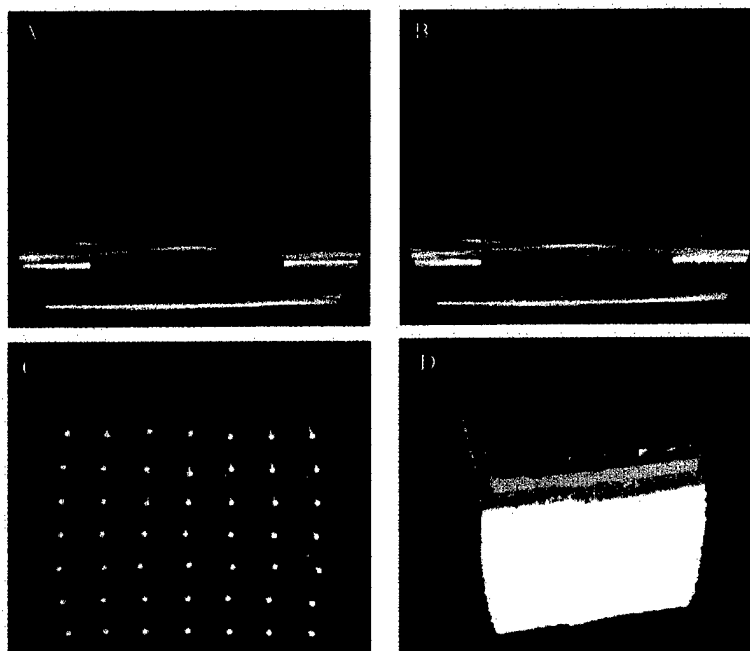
The CT image of the central vertical plane of the Truth Cube after segmentation in both the unloaded (A) and maximally uniaxial compressed (B) states. Note the registration marker off to the side. Internal sphere trajectory and location in the central plane (C) (blue=unloaded, green=5%, red=12.5%, yellow=18.25% strain). Outer surface of the cube in its four strain states (D).
